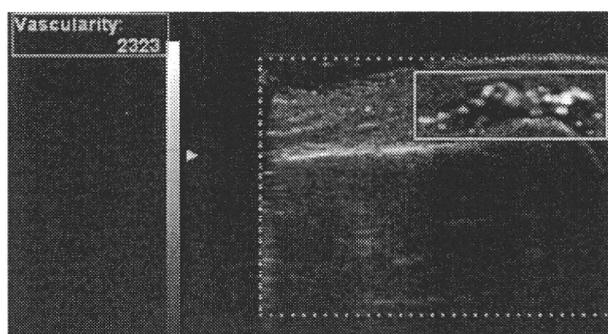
An image of finger joint ultrasonography (right 5th metacarpophalangeal joint). Each joint was scanned as described in the Patients and Methods section. The white line box indicates the region of interest (ROI) that was located at synovial vascular flow. Pixels of vascular flow inside the ROI were measured by the ultrasonographic program and displayed at the upper left corner of the monitor.
